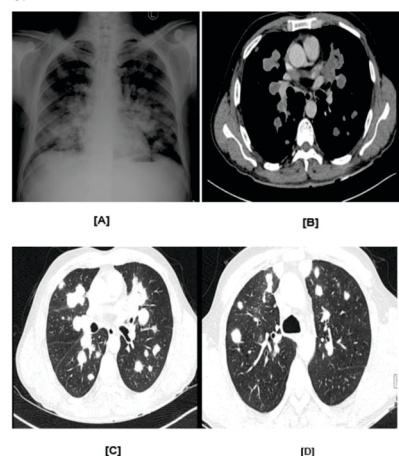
NHL with lung metastasis in a 43-year-old HIV male. The chest radiograph shows multiple well-defined lung nodules within the bilateral lung fields. No mediastinal Lymphadenopathy as it is a not a feature in AIDS-related NHL. These findings are confirmed by computed tomography showing multiple heterogeneously enhancing parenchymal and pleural based variable sized nodules.
